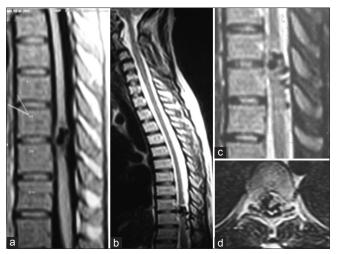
(Patient 3) (a) T1-weighted; (b) T2-weighted sagittal magnetic resonance (MR) images showing the flow voids of a perimedullary arteriovenous malformation; (c) Enlarged T2-sagittal; and (d) axial MR images showing the venous aneurysm situated on the right anterior aspect of the spinal cord with perimedullary flow voids
